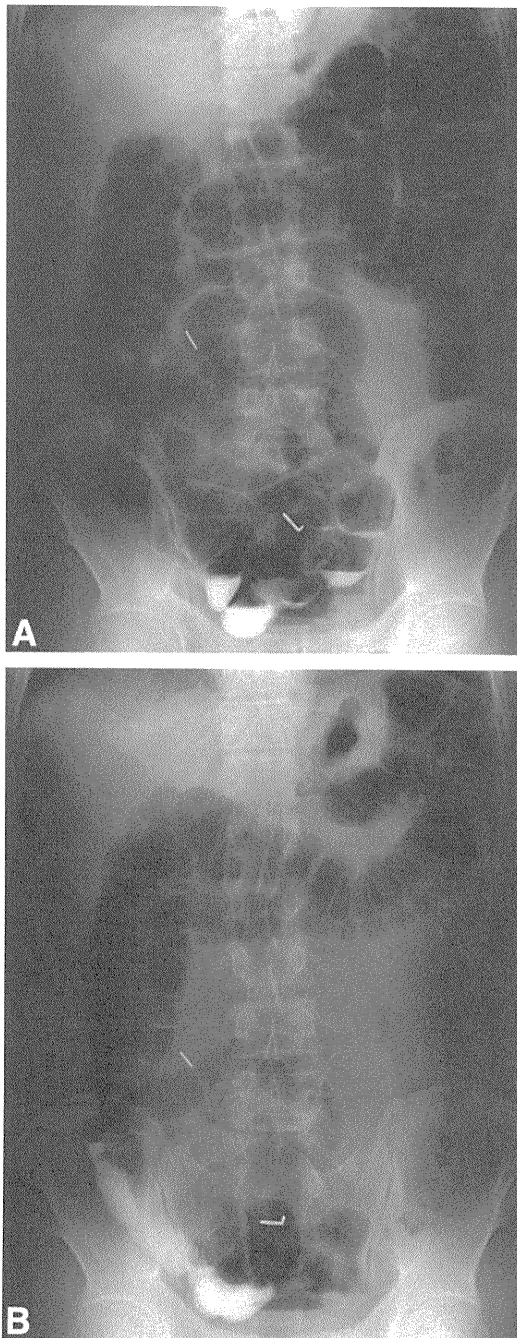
Abdominal radiographs after double-balloon enteroscopy (DBE) via the transanal approach with air insufflation. A, Extreme residual gas retention is visible just after DBE in the small and large bowels (classified as grade 5). B, Severe residual gas retention is still visible in the small and large bowels 3 hours after DBE (grade 4).
